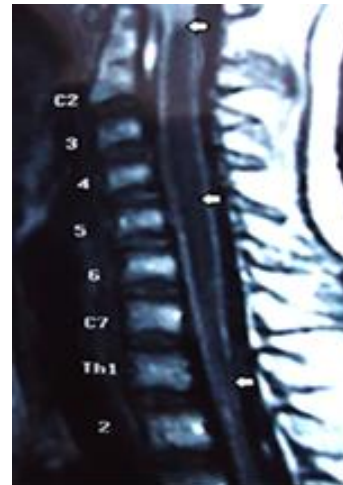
MRI of syringomyelia affecting C₁–Th₁ spinal segment
